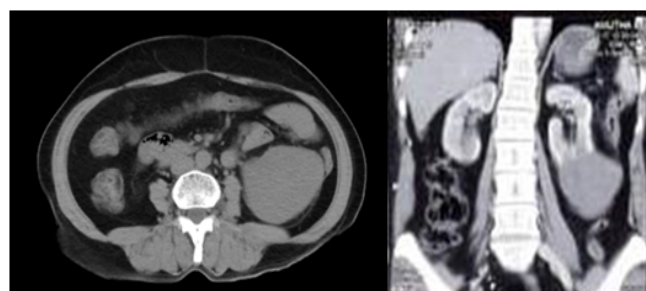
Computed tomography of abdomen showing exophytic tumour (7 × 6.5 cm) originating from the lower pole of the left kidney, breaching the perirenal fat and Gerota's fascia.
